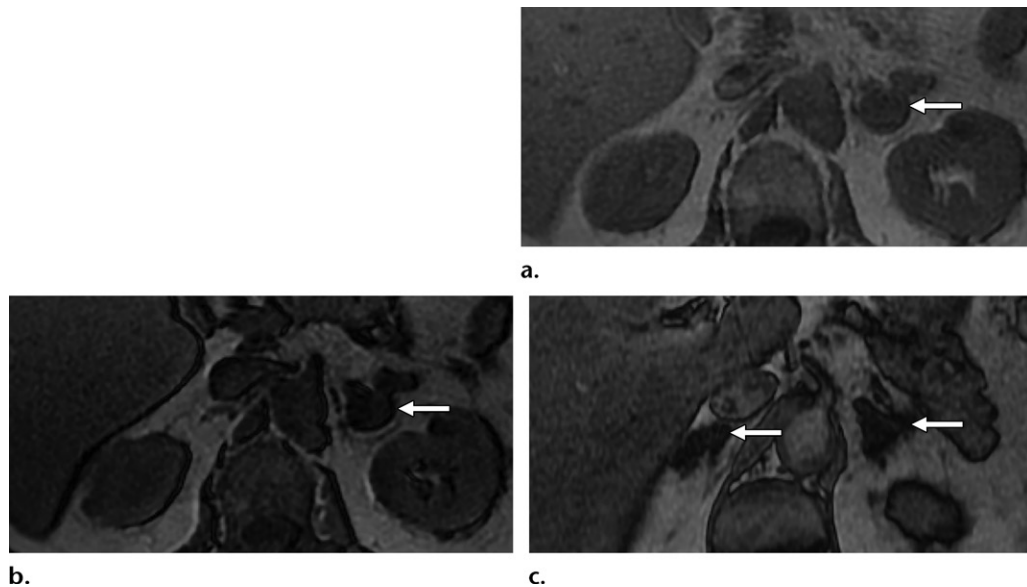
Adrenal hyperplasia versus adrenal adenoma in Conn syndrome. (a, b) Axial chemical shift in-phase (a) and out-of-phase (b) MR images in a patient with hyperaldosteronism show a left adrenal nodule with signal loss (arrow), a finding in keeping with an adenoma, which was presumed to be the cause of primary hyperaldosteronism. Hyperaldosteronism persisted following a left adrenalectomy. (c) Axial out-of-phase MR image obtained at initial imaging shows thickening of the left lateral limb and right adrenal gland limbs (arrows). A final diagnosis of bilateral hyperplasia causing hyperaldosteronism was established. This form of Conn syndrome generally requires treatment with medical therapy rather than surgery. Mean adrenal limb measurements (>5 mm, 100% specificity) can aid in differentiating aldosterone-producing adenoma from bilateral adrenal hyperplasia in primary hyperaldosteronism.
